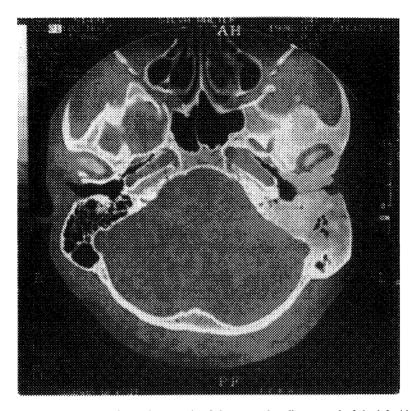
Axial CT scan: shows the stenosis of the external auditory canal of the left side.
